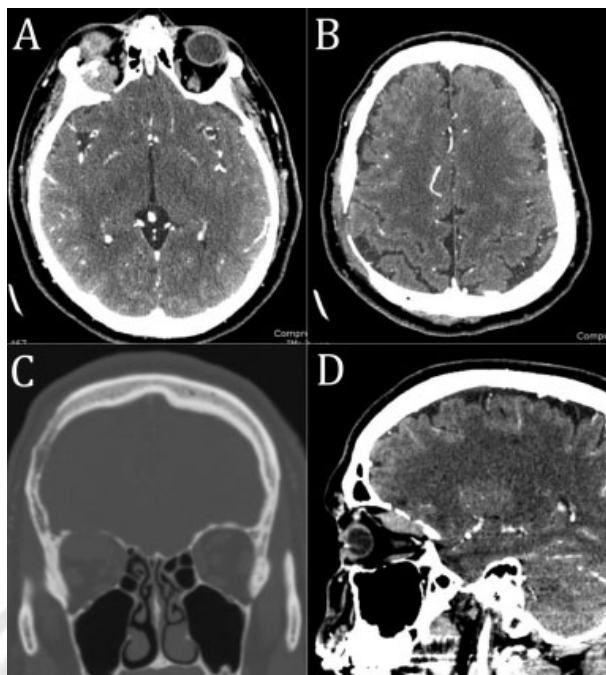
Preoperative computed tomography scan showing the right intraorbital part of the arteriovenous malformation (AVM), with three small calcifications (a) and the right frontoparietal part of the scalp AVM with skull erosion (b). Coronal (c) and sagittal (d) reconstructions evidence the interruption of the right orbital roof.
